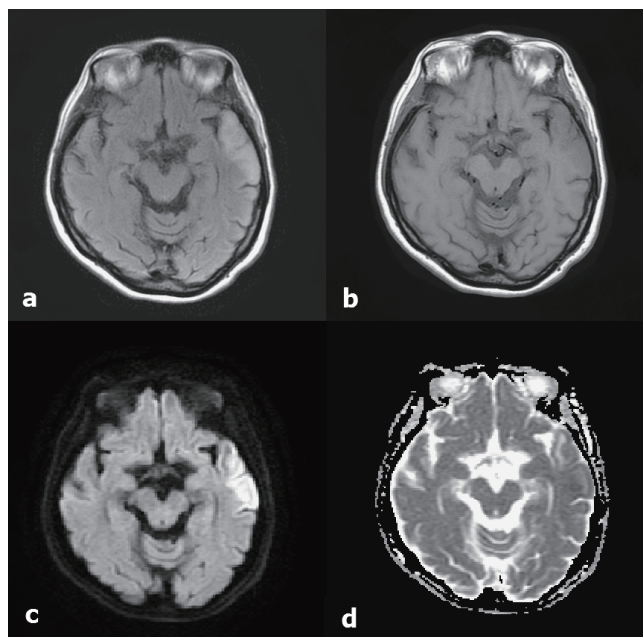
Brain 1.5-T magnetic resonance imaging (MRI) performed 2 days after admission showing a high signal lesion on T2-weighted imaging (a) and a low signal on T1-weighted imaging (b) in the left lateral temporal lobe. Both cortical and white matter are involved. On diffusion-weighted imaging (c), a high signal was seen in the cortical gyriform pattern, with an iso signal on apparent diffusion coefficient sequences (d) in the same region.
